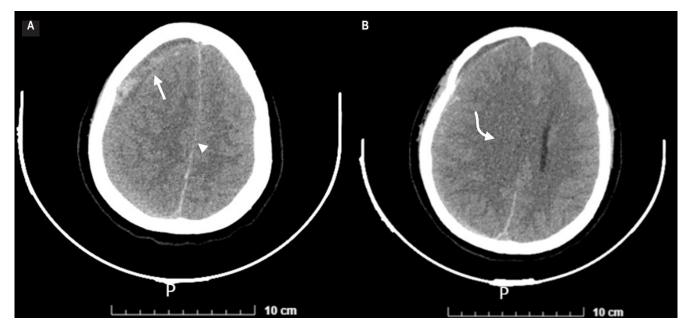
Cranial Computed Tomography. A. Chronic right subdural hematoma (arrow), with a 12 mm midline shift (arrowhead). B. Ventricular involvement (curved arrow). Author's File.
